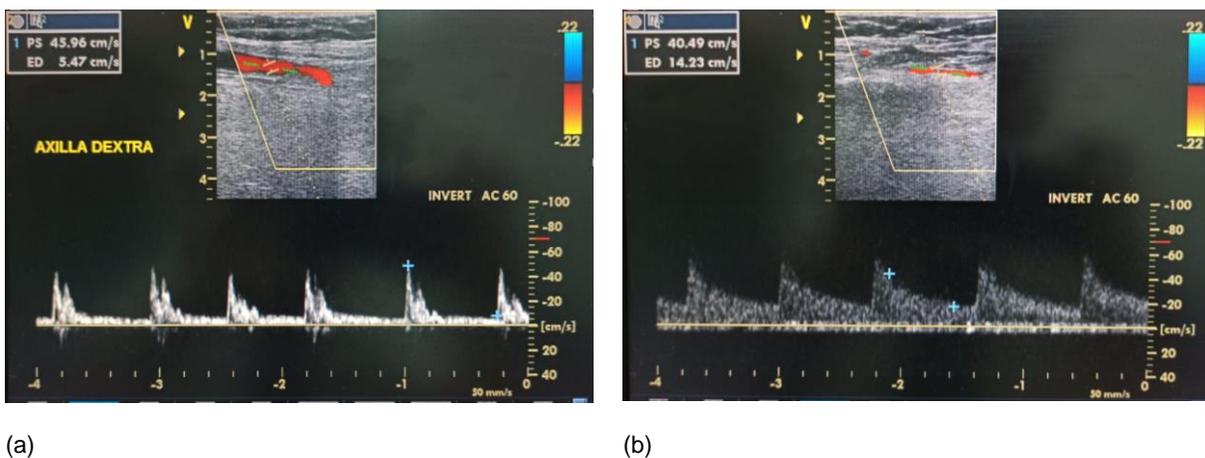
Duplex ultrasonography of (a) the right axillary artery shows a biphasic waveform (peak systolic velocity/PSV = 45.96 cm/s) and of (b) the right proximal brachial artery shows a monophasic waveform (PSV = 40.49 cm/s). Both show a reduced velocity.
